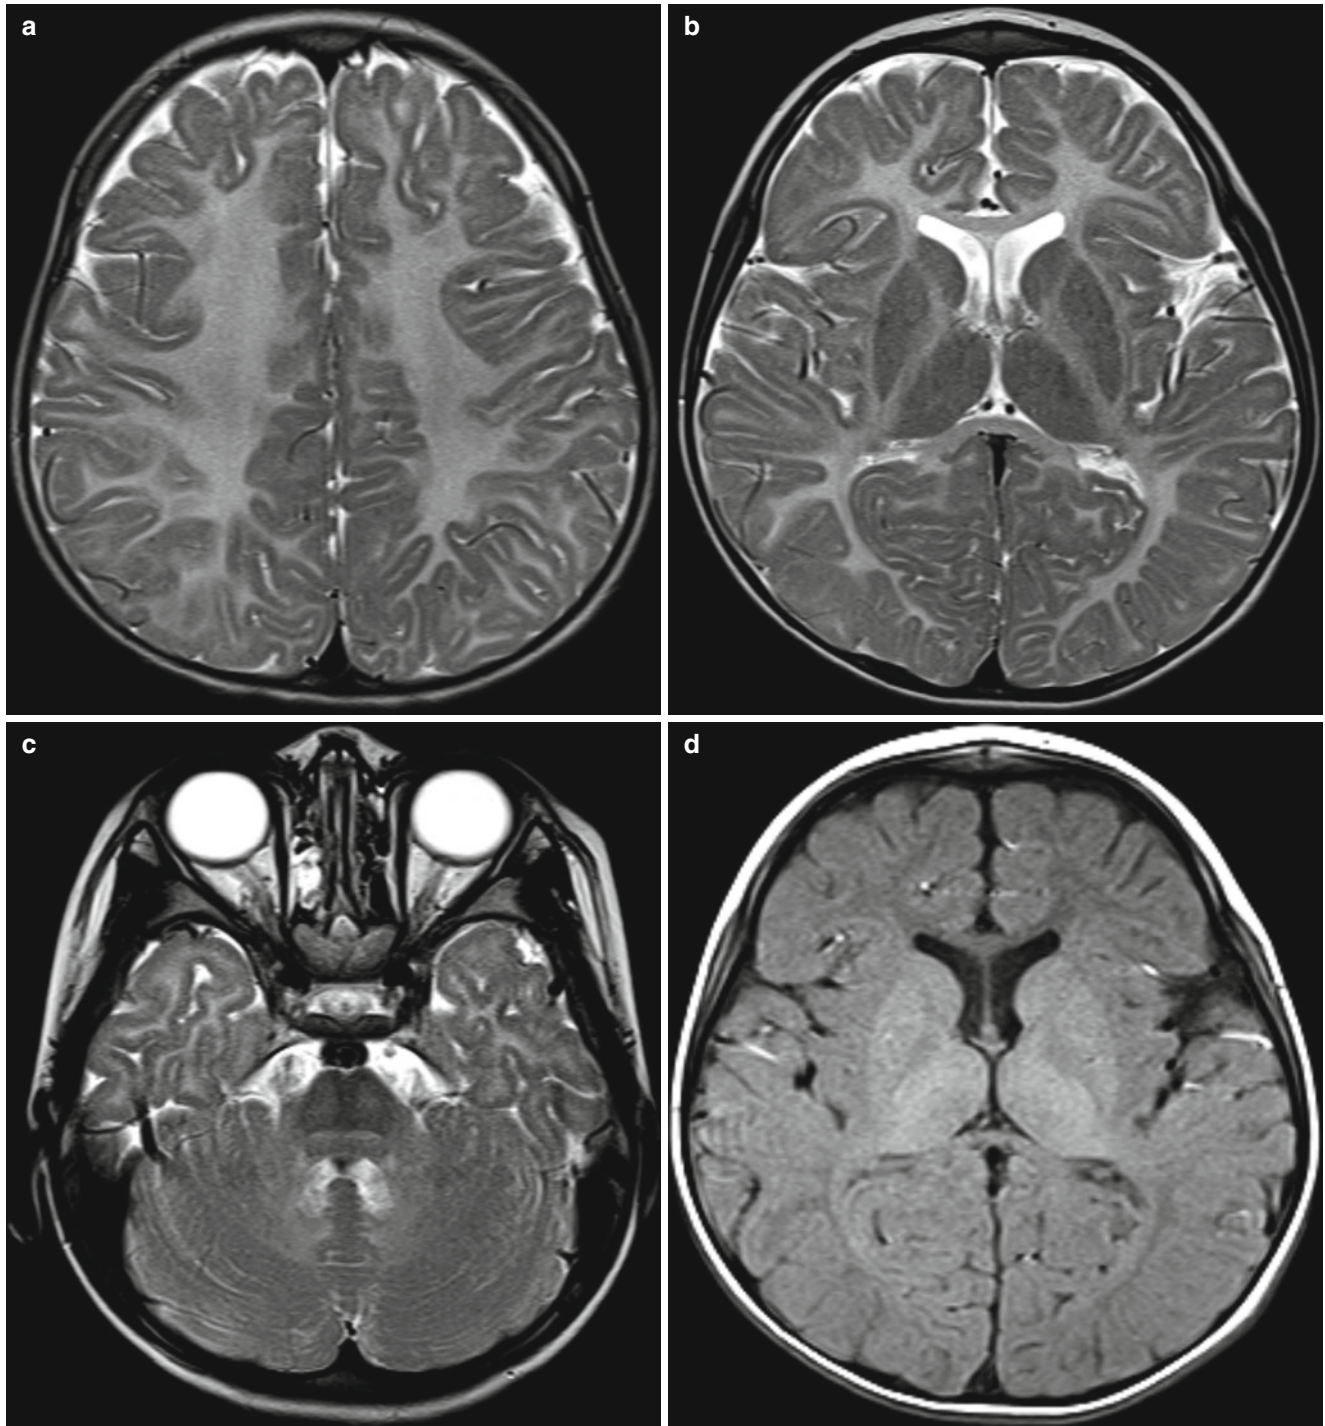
Pelizaeus-Merzbacher disease in a 5-year-old boy. (a–c) T2-weighted images show high-signal intensity of the entire white matters, including internal capsule and cerebellar deep white matters.
